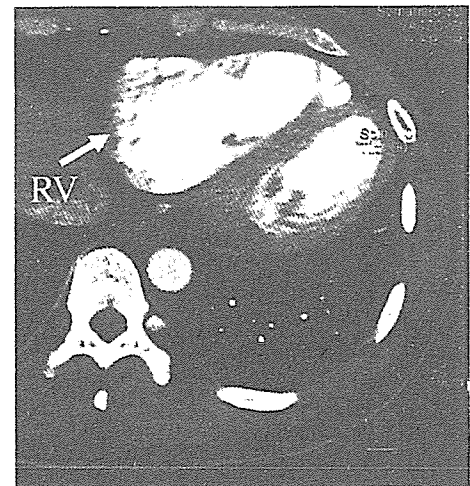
Computed tomography with contrast demonstrated the dilated right ventricle (RV) and the presence of epicardial and intramyocardial fat deposits in the RV.
